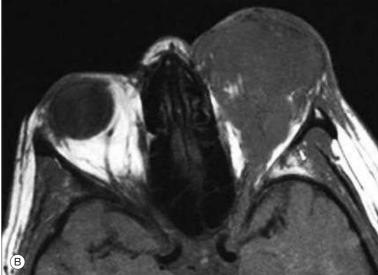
Malignant Melanoma. (A) Recurrent secondary orbital malignant melanoma in an enucleated socket from extrascleral extension of a uveal tumor. (B) Computed tomography scan showing a homogeneous medium density mass filling the orbit.
